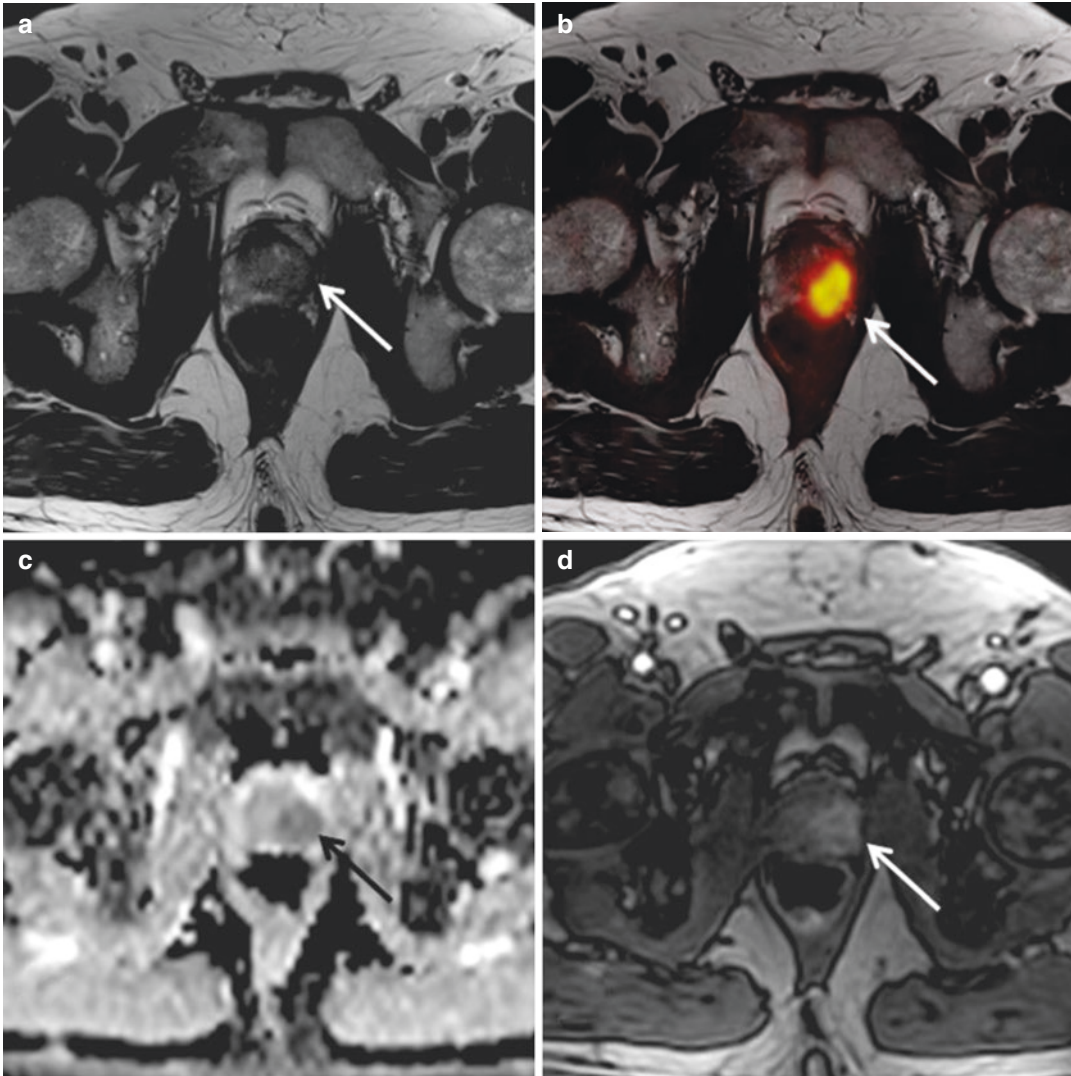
^{68}Ga PSMA-11 PET/MR images from a patient with biopsy-proven Gleason 4 + 4 prostate cancer at initial staging. The images demonstrate exemplarily the combination of multi-parametric MRI with PET. The prostate harbors a large hypo-intense lesion of the left peripheral
